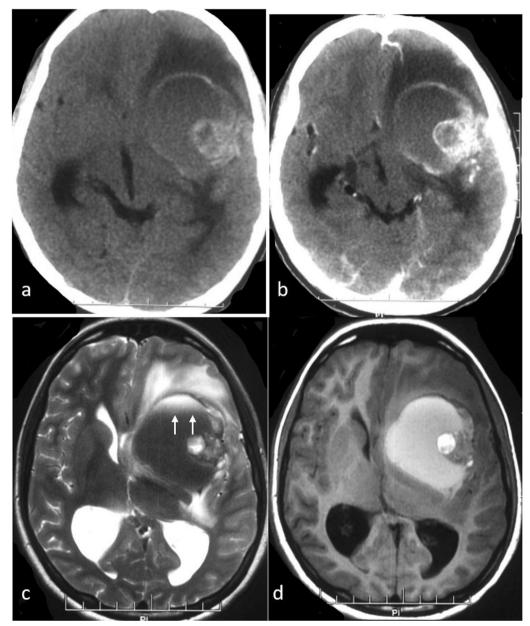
The axial plain (a) and contrast CT head (b) reveals heterogeneous hyperattenuating mass at left gangliocapsular region with moderate perilesional edema and showed moderate post-contrast enhancement with internal non-enhancing cystic component. The axial T2 (c) and T1 (d) images demonstrate the solid-cystic nature of the lesion, the cystic component showing hypointense signal on T2 and hyperintense signal on T1 with fluid–fluid level (white arrows). The solid component of the lesion shows heterogeneous signal on both T2 and T1 images
